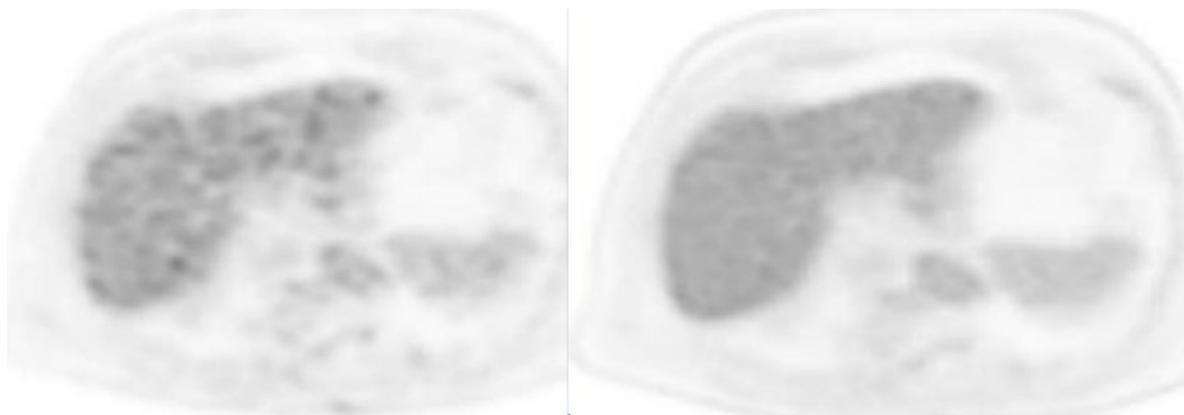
Patient 79 kg, 4,4 mCi FDG dose injected. Reconstruction OSEM and DPR respectively. OSEM recon represent COV liver of 9,8 % vs COV liver DPR of 4,37 %.
